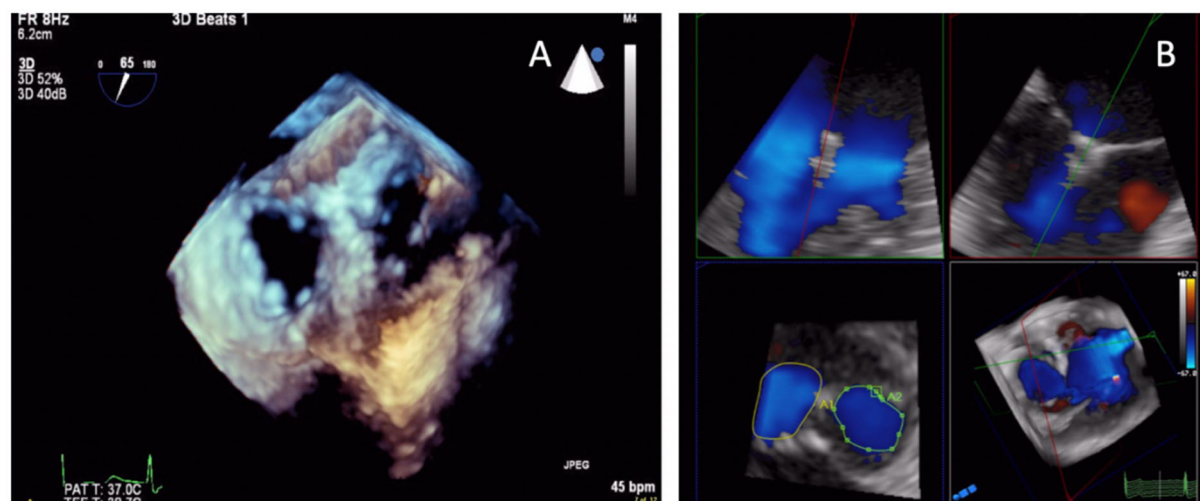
Transesophageal 3D view of the double orifice created by MitraClip, a percutaneous mitral valve repair device (A); quantitative assessment of valve area of the double orifice by MPR; Multi-planar reconstruction (B)
